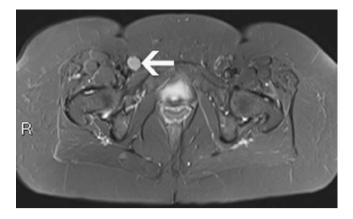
Axial STIR MRI scan demonstrating a right inguinal node in a female patient presenting with a painful right groin mass. Excision biopsy confirmed metastatic squamous cell carcinoma
